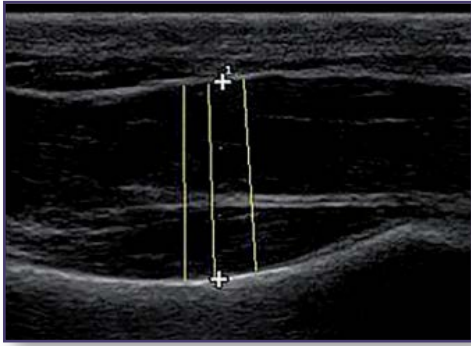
Ultrasound image of the flexor hallucis brevis with 3 thickness measurements (yellow lines).
